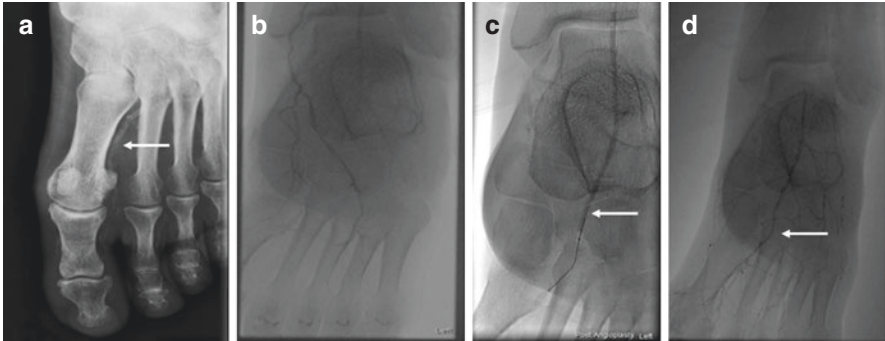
Metatarsal artery angioplasty. (a) Radiograph of the right big toe demonstrates a heavily calcified first metatarsal artery (arrow). Clinically, a non-healing ulcer persists at the big toe despite previous successful tibial revascularization. (b) Foot angiogram demonstrates an occluded distal dorsalis pedis and first metatarsal arteries. (c) Crossing of the distal dorsalis pedis and first metatarsal occlusion was performed successfully and this is followed by balloon angioplasty (arrow) of the dorsalis pedis and first metatarsal arteries. (d) Direct vascular flow is restored into the big toe (arrow) where the non-healing ulcer is present
